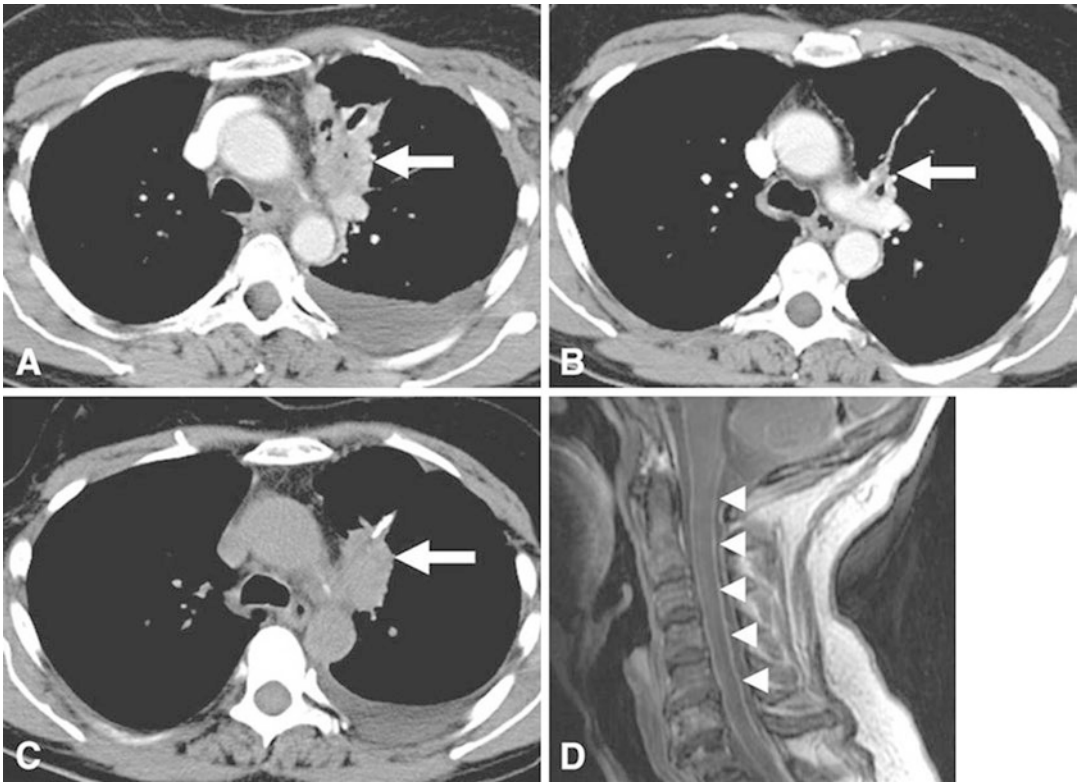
A 50-year-old woman with lung adenocarcinoma harboring sensitizing EGFR mutation. (a) Baseline chest CT before therapy demonstrated an irregular mass in the left upper lobe, measuring 3.1 cm. (b) The patient started treatment with erlotinib and demonstrated marked tumor decrease as a response to therapy. After 11 months of therapy, the left upper lobe lesion measured 0.8 cm (arrow), which was the smallest measurement since the baseline. Subsequently, the lesion started to grow slowly, and at 15 months of therapy, the lesion measured 1.4 cm, meeting the criteria for progression by RECIST 1.1
